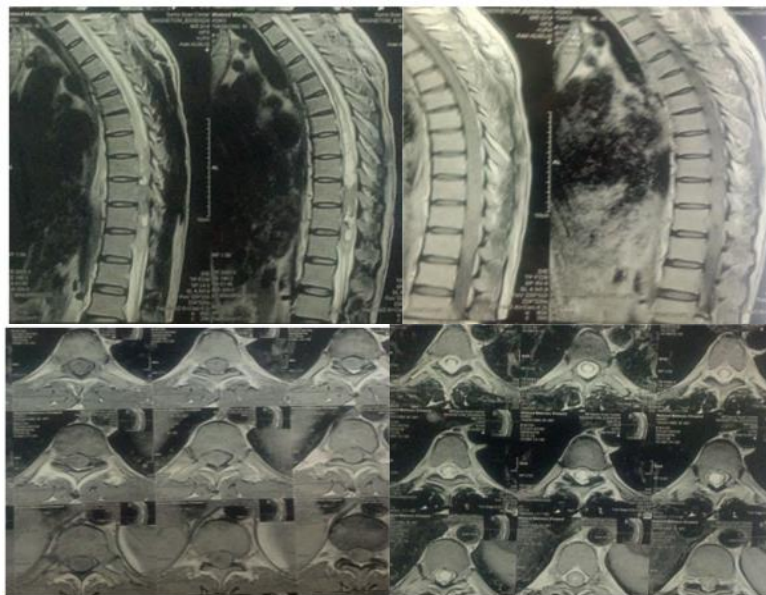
MRI post T1 with contrast axial and sagittal views and T2 WI axial and sagittal study revealed subtotal excision of intramedullary spinal ependymoma WHO grade 1 also intraoperative cord enlargement and myelotomy.
